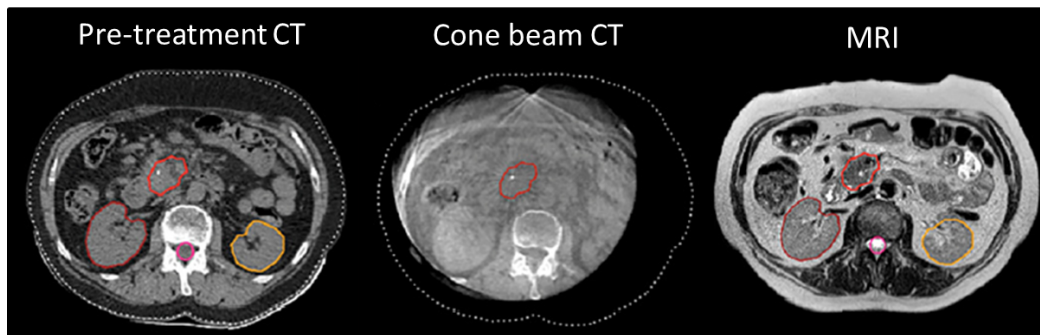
Axial view of a patient with a pancreatic tumour imaged with a conventional CT scan used for planning (pre-treatment CT). The poor soft-tissue contrast in the CT and the CBCT images required the use of implanted fiducials to locate the tumour position accurately. On the MRI, there is a direct visualization of the tumour, which avoids the need for fiducials (Figure from [30]).
